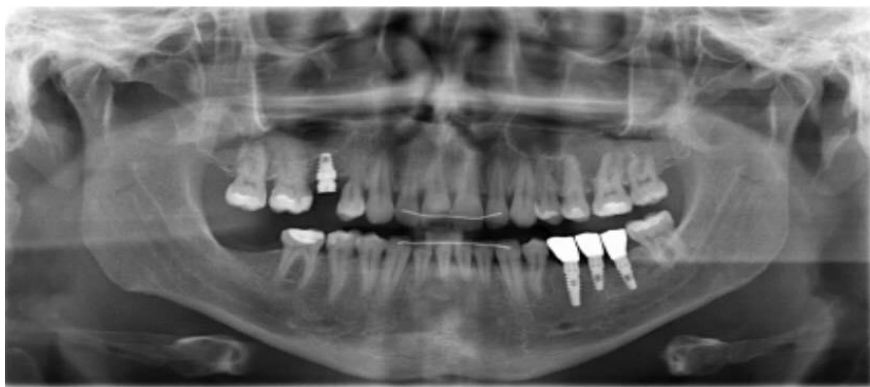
Control panoramic roentgen image after 36 months
